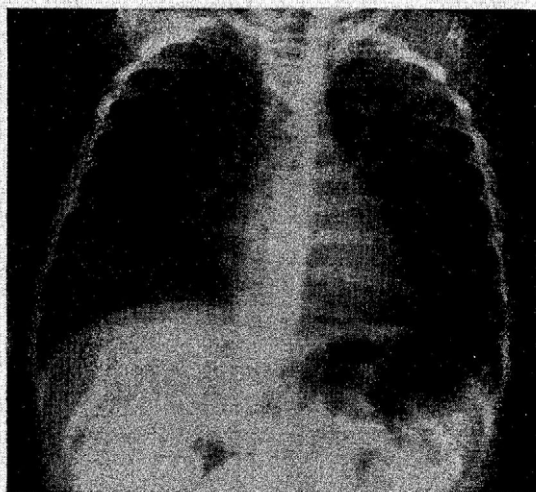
Chest x-ray (anteroposterior view) of ten-month-old girl showing radiopaque mass in right lower thorax.
